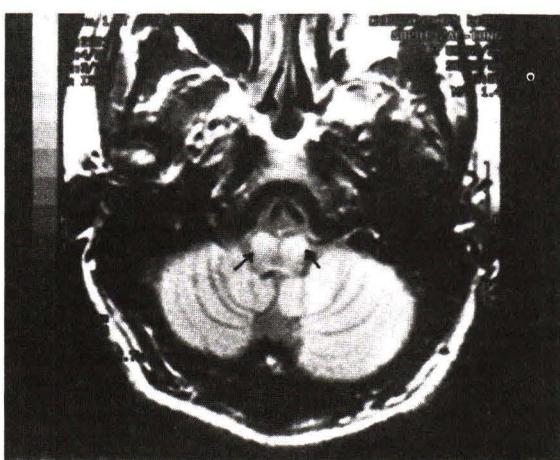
MRI (PD) section at the level of upper medulla revealed increased signal intensity and bilateral enlargement of inferior olives (arrow).
